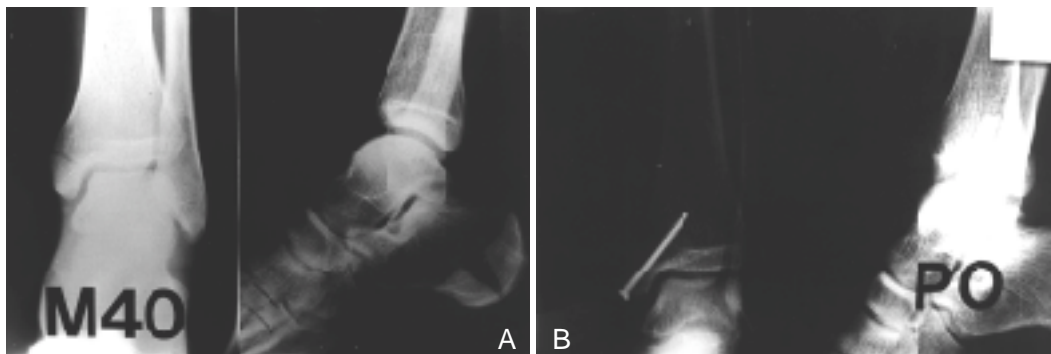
40-year-old man. Initial radiograph showed fracture gap of medial malleolus within 3mm.
